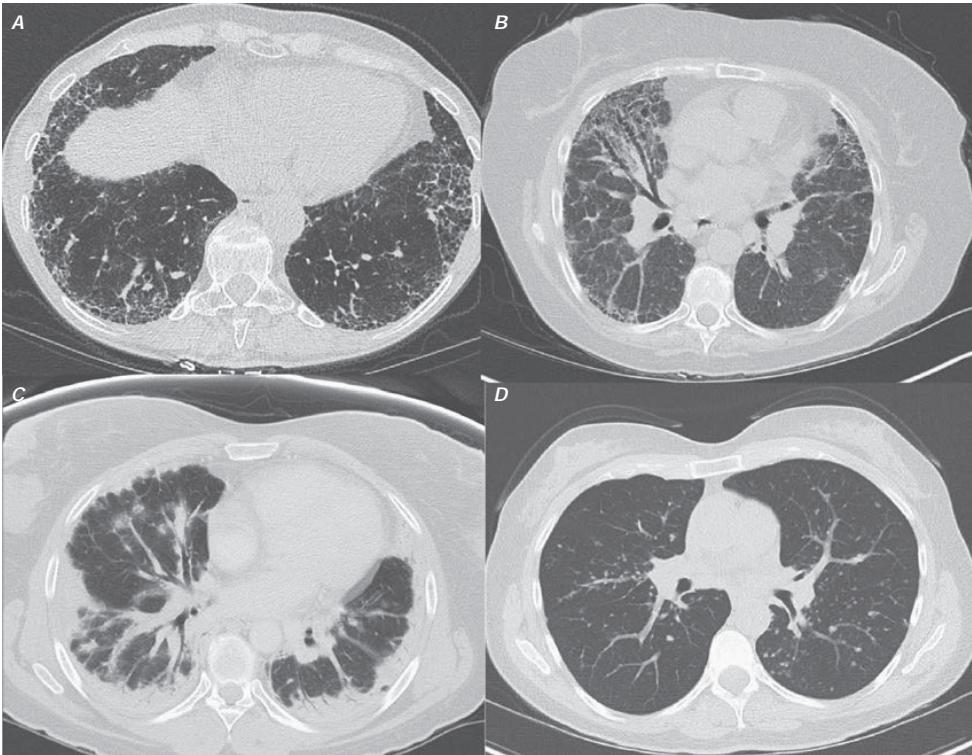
Chest CT imaging and interstitial lung disease. A. Idiopathic pulmonary fibrosis (IPF): Classic findings of IPF (apparent on this image) include a posterior, basilar predominance of subpleural reticular markings and more advanced features of pulmonary fibrosis including traction bronchiectasis and honeycombing. This constellation of findings is often referred to as a usual interstitial pneumonia (UIP) pattern. B. Nonspecific interstitial pneumonia (NSIP): Chest CT findings of NSIP can overlap with those of a UIP pattern but tend to include a bilateral, symmetric pattern that presents with a greater percentage of ground-glass opacities than is apparent in a UIP pattern. Additional unique findings include more diffuse imaging abnormalities with a predominance not limited to the lung bases, imaging abnormalities that spare the subpleural regions, and thickening of the bronchovascular bundles (as is apparent in the right mid lung zone on this image). C. Cryptogenic organizing pneumonia: Chest CT findings include patchy, sometimes migratory, subpleural consolidative opacities (as is apparent on this image) often with associated ground-glass opacities. Peribronchiolar or perilobular opacities can be present, and sometimes a rim of subpleural sparing (often referred to as a reversed halo or atoll sign) can be seen, which can help to aid in the diagnosis. D. Sarcoidosis: Sarcoidosis can present with varied imaging abnormalities, but a pattern of mediastinal and hilar lymphadenopathy with a pattern of reticular-nodular opacities involving the bronchovascular bundles (apparent in this image) are common features. Additional findings can include diffuse small nodules in a miliary pattern, larger nodular opacities, extensive ground-glass infiltrates, and mosaic attenuation suggestive of small airways involvement, and, in more advanced cases, signs of pulmonary fibrosis.
